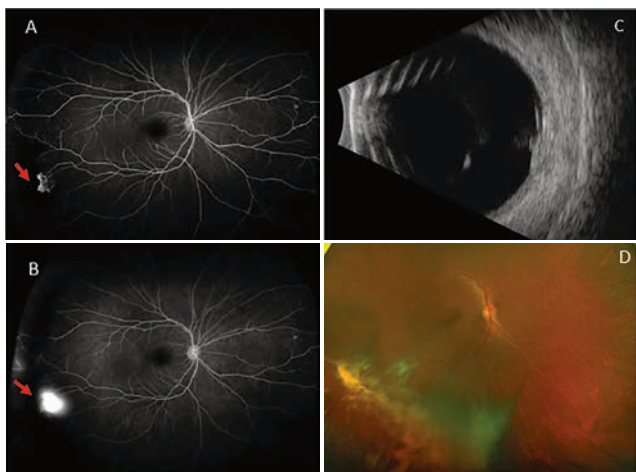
A 31-year-old man with HbSS disease and 20/20 vision presented with a small area of sea-fan neovascularization depicted on UWF-FA, panel A (early frame, red arrow) and panel B (late frame, red arrow). Observation and follow up in six months was advised. He was lost to follow up and presented urgently 2 years later with drop in vision to hand motions due to vitreous hemorrhage (Panel C, B-scan ultrasound). Scatter laser was applied once the vitreous hemorrhage cleared centrally. Subhyaloid and vitreous hemorrhage overlie the etiologic small sea fan neovascular lesion. (UWF-F, Panel D).
